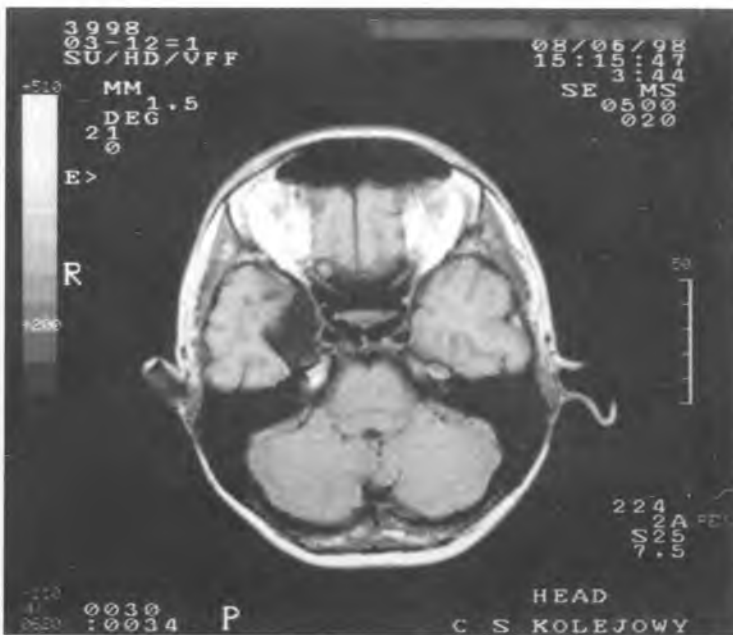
MRI of the head 10 months later
